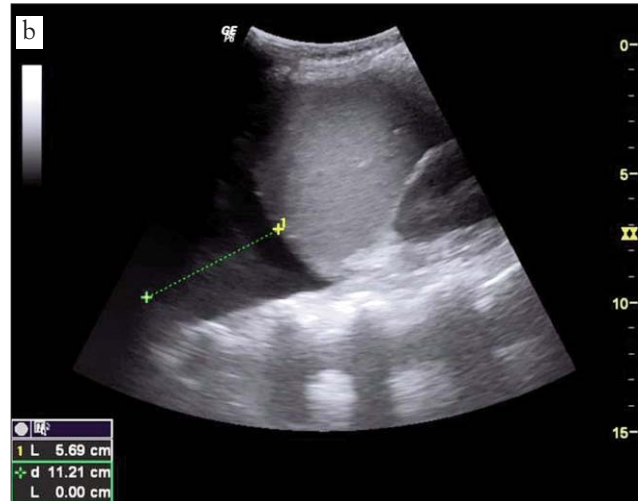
a, b - Abdominal ultrasonography during admission
